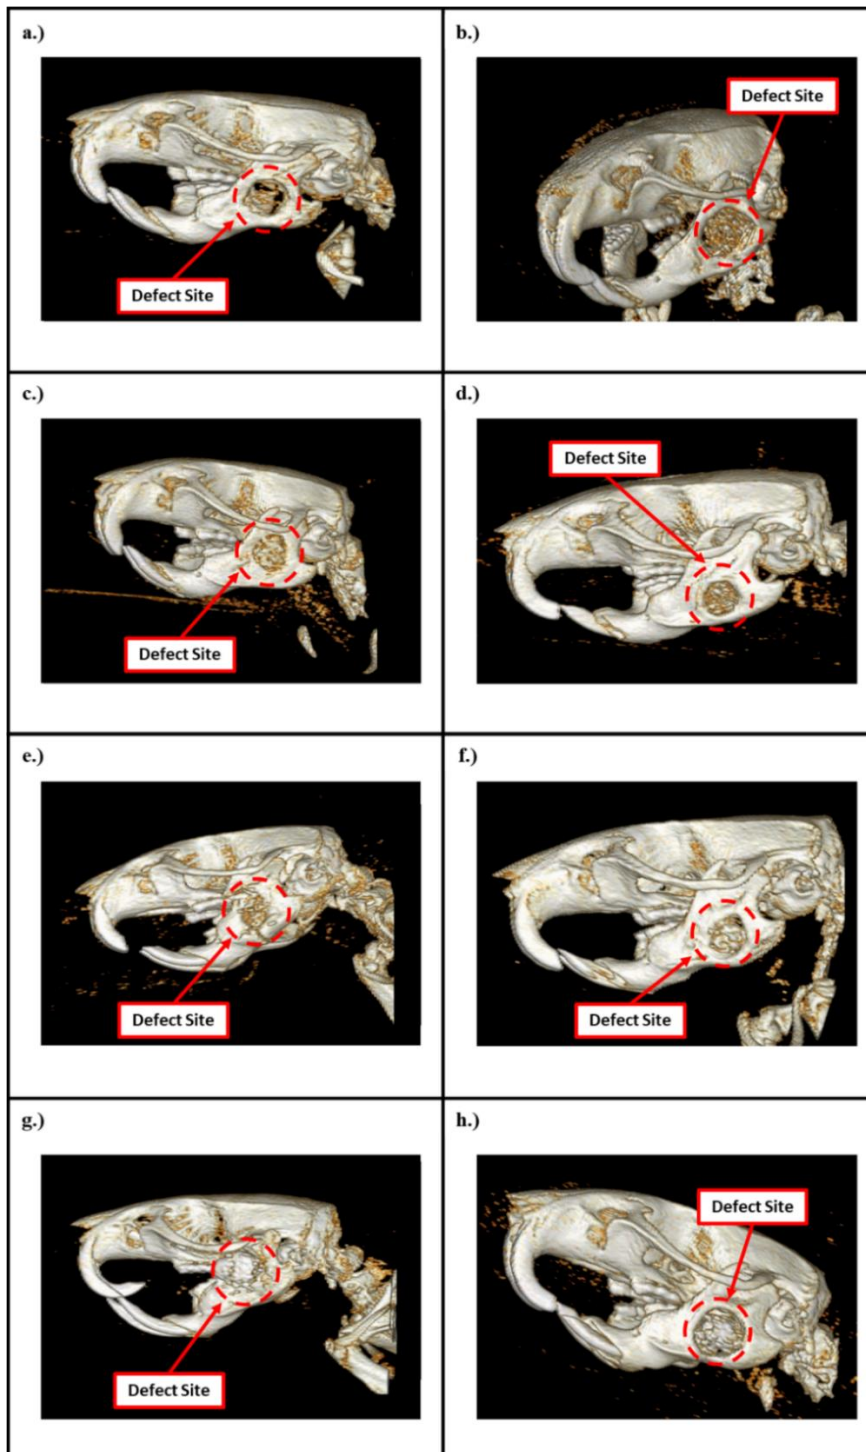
Mandibular defect model CT 3D renders. Test articles designated M-1 (a & b) and S-1 (c & d) as compared with predicate materials, BioOss Collagen® (e & f) and Syntoss® (g & h) at 1-month and 2-month time points respectively.
